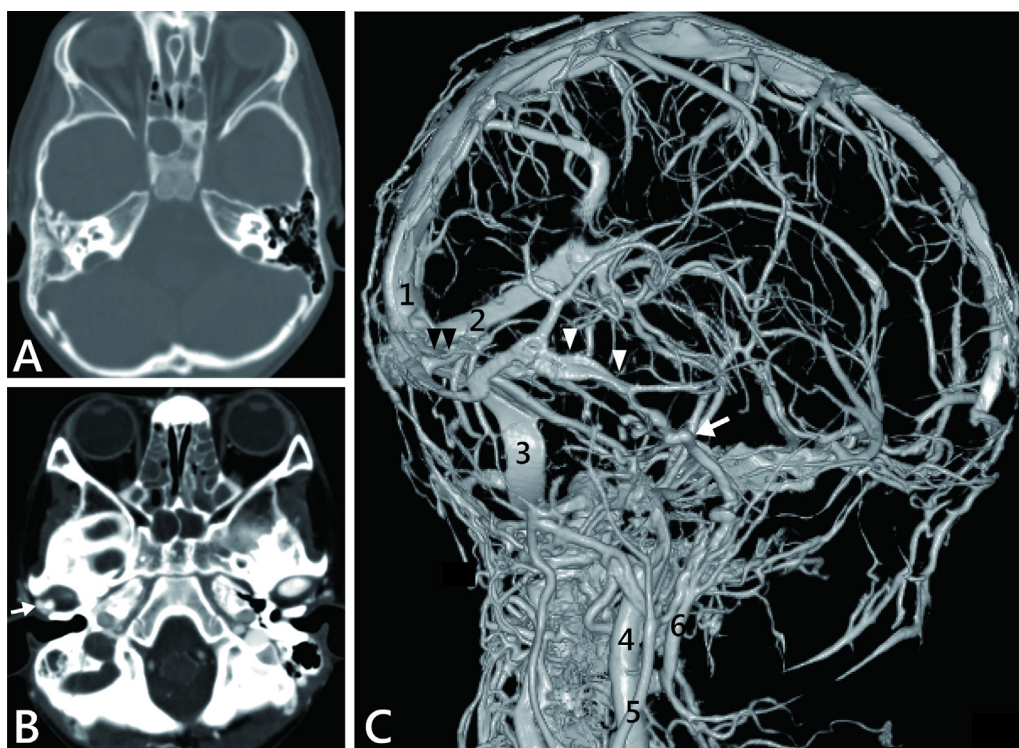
(A) Bone window of the axial CT image. Soft tissue density in the mastoid without surrounding bone destruction is seen. (B) Enhancement defect of right sigmoid sinus is seen in the axial image of the enhanced CT. Right postglenoid foramen is strongly enhanced in the glenoid fossa (white arrow). (C) Three-dimensional CT images of the cranial venous systems on right lateral views. The flow of right transverse sinus is defected (black double arrowhead), and the contour of sigmoid sinus is lost. The petrosquamosal sinus (PSS) drains through the postglenoid foramen (white arrow) into the external jugular vein via connecting branches with the retromandibular vein. (1) Superior sagittal sinus; (2) Left transverse sinus; (3) Left sigmoid sinus; (4) Right internal jugular vein; (5) Right external jugular vein; (6) Right retromandibular vein.
